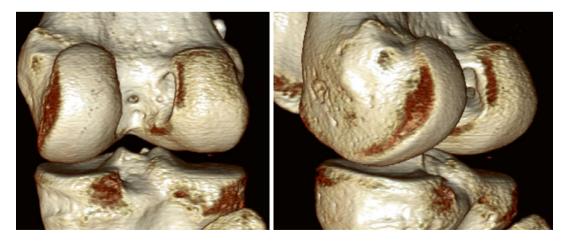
3-D CT reconstructions showing an enlarged femoral tunnel
